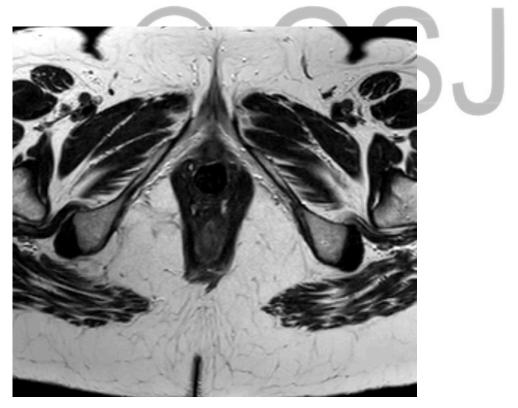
PELVIC MRI CONFIRMING THE DIAGNOSIS OF SUBURETERAL DIVERTICULUM
